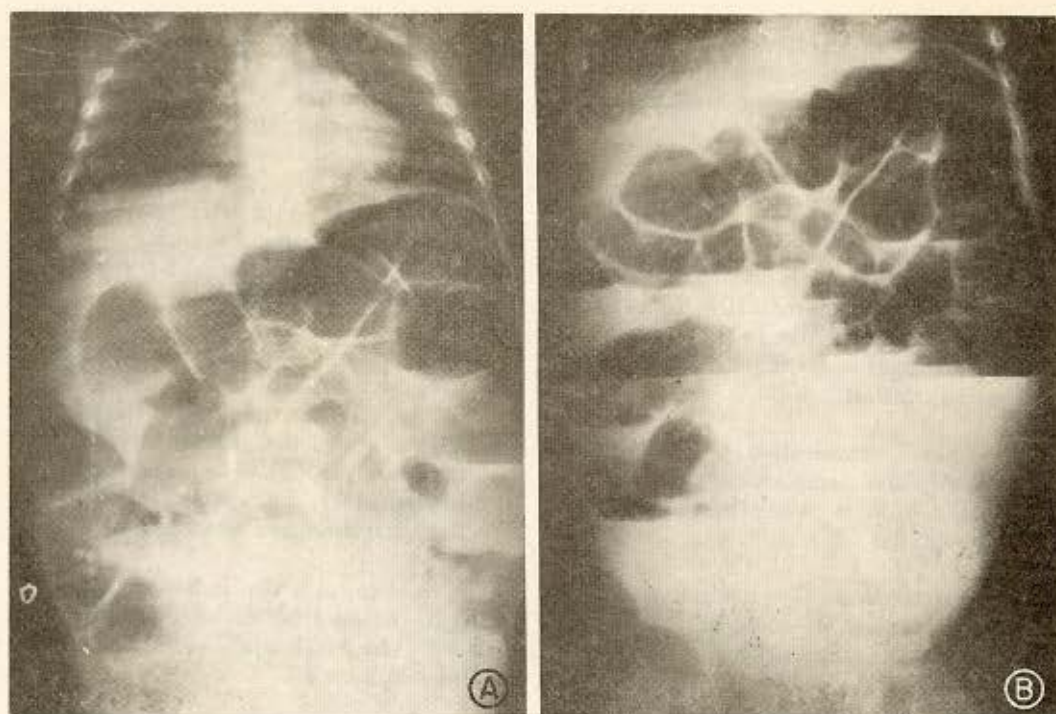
A) Radiography in horizontal position: lump of *Ascaris* at the right iliac fossa; B) Radiography in a standing position: intestinal distension, liquid levels, edema of the wall and free liquid in the peritoneum.
